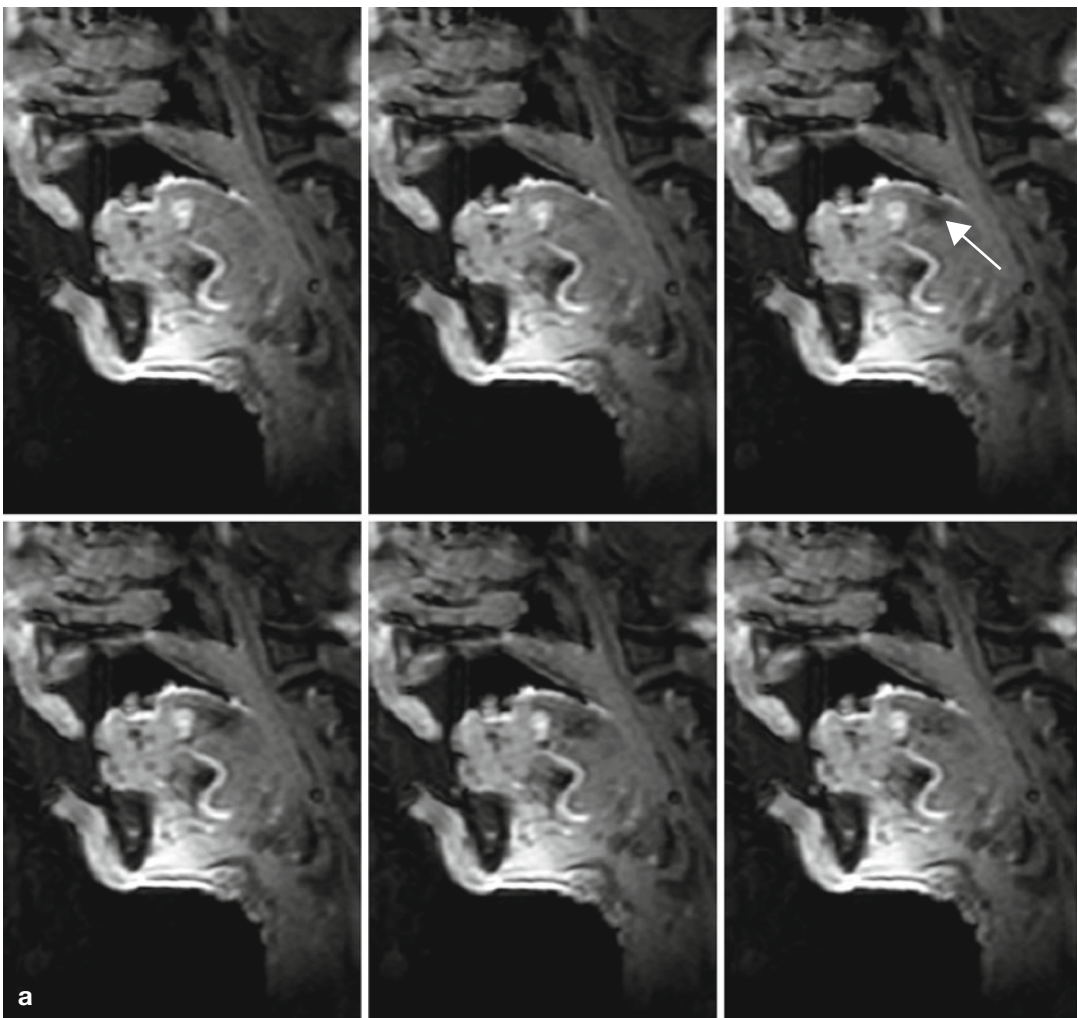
It is difficult to depict the temperature increase around a laser fiber on these T1-weighted gradient-echo images. A slight drop in signal intensity can be seen around the laser tip (*arrow*) positioned in the tongue base
